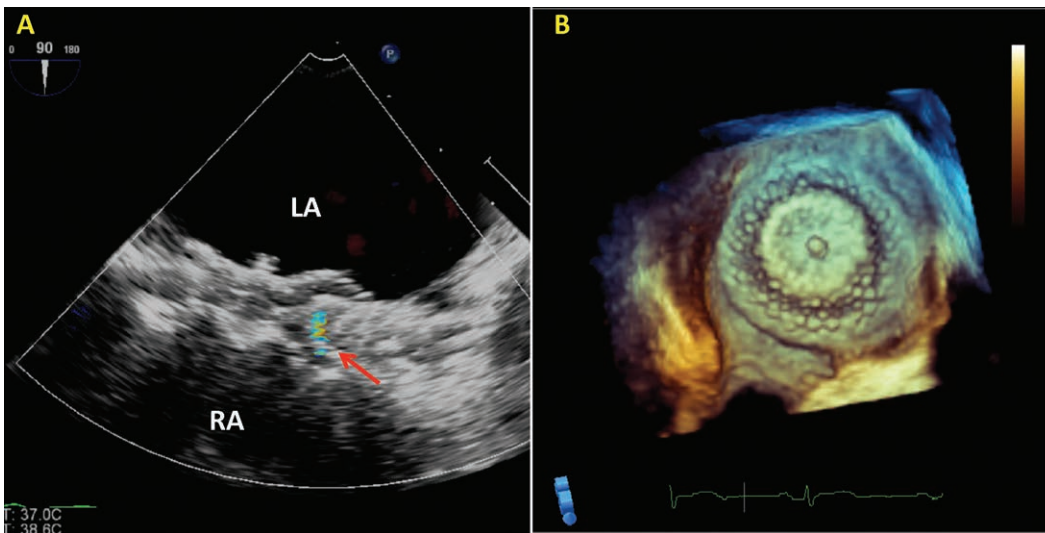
Functional assessment of atrial septal defect (ASD) closure device. (A) A well-seated device (Amplatzer™ ASD occluder) with small residual shunt detected by color Doppler noted immediately after deployment (red arrow). (B) 3D volume rendered image of the occluder as viewed from the left atrium.
